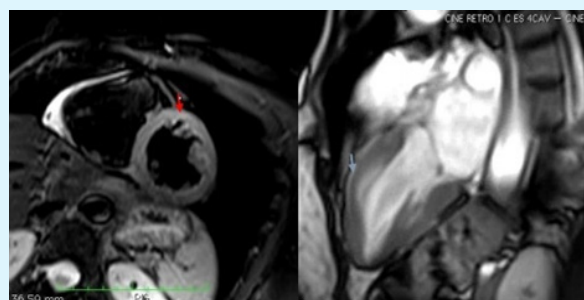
MRI appearance of myocardial edema without late gadolinium enhancement (red arrow). Hypokinesia of mid-segments (blue arrow).
